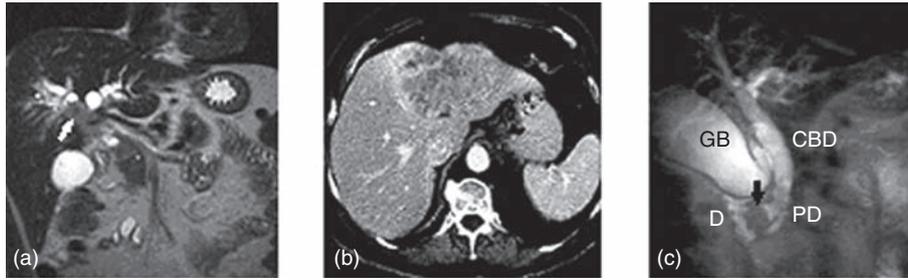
Three types of cholangiocarcinoma based on anatomic location. (a) Hilar cholangiocarcinoma. A coronal magnetic resonance (MR) image through the upper abdomen shows a mass (arrow) at the confluence of the left and right hepatic ducts causing proximal intrahepatic biliary ductal dilatation. (b) Intrahepatic cholangiocarcinoma. An axial computed tomography (CT) image shows a large heterogeneous mass occupying most of the left liver and causing umbilication of the liver surface. (c) Distal cholangiocarcinoma. A magnetic resonance cholangiopancreatography (MRCP) coronal image shows a mass (arrow) at the distal common bile duct (CBD) near its confluence with the pancreatic duct (PD) before entry into the duodenum (D). The proximal bile duct and gallbladder (GB) are distended.
